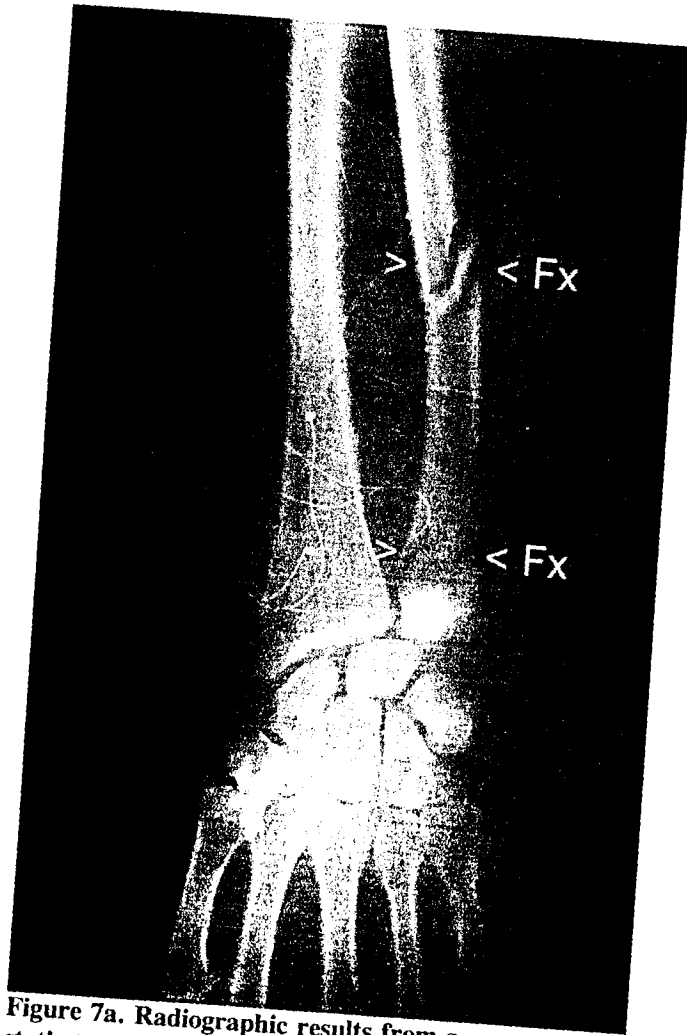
Radiographic results from a representative static test (right arm, in supination).
